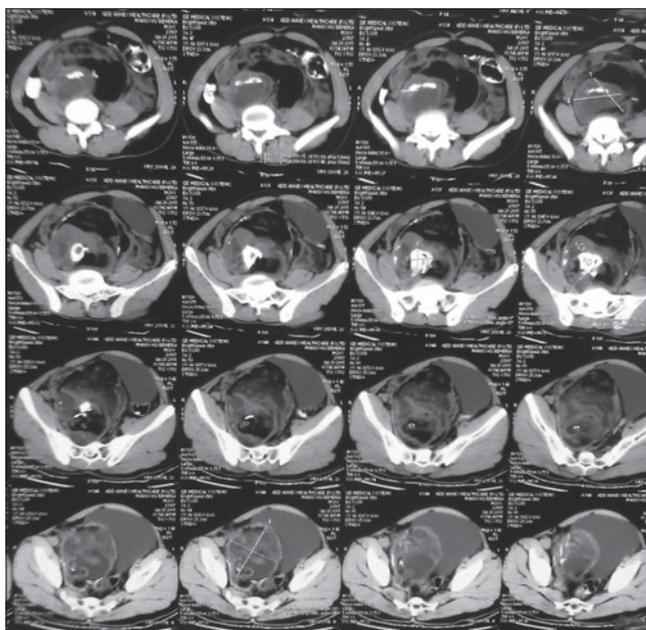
Axial images of contrast-enhanced computed tomography pelvis showing well-defined heterogeneous retroperitoneal mass lesion present in the right side anterior to the psoas muscle, pushing the bladder to the left anteriorly containing fatty tissues and calcifications
